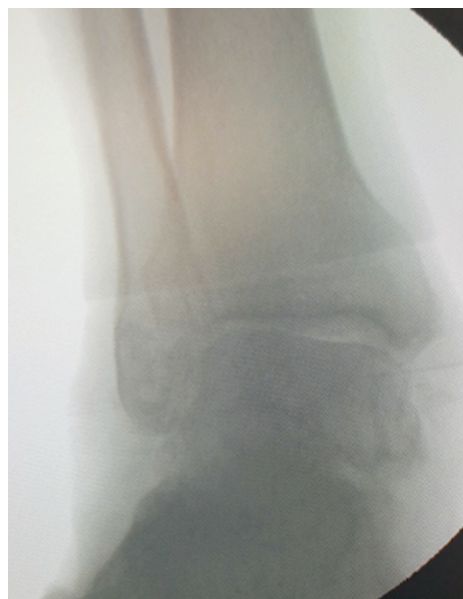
Stress eversion radiograph demonstrated 23 degrees of eversion of the tibio-talar joint.
